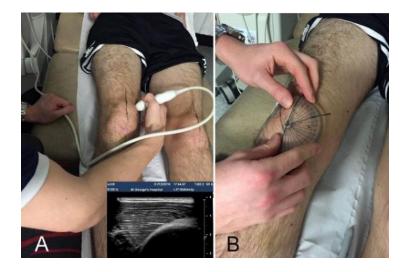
Measuring the fibre angle of the VMO. A: the ultrasound probe was rotated until the muscle fibres were seen as parallel white lines (inset); B: the position of the probe was marked, and the fibre angle was measured with a clear protractor
